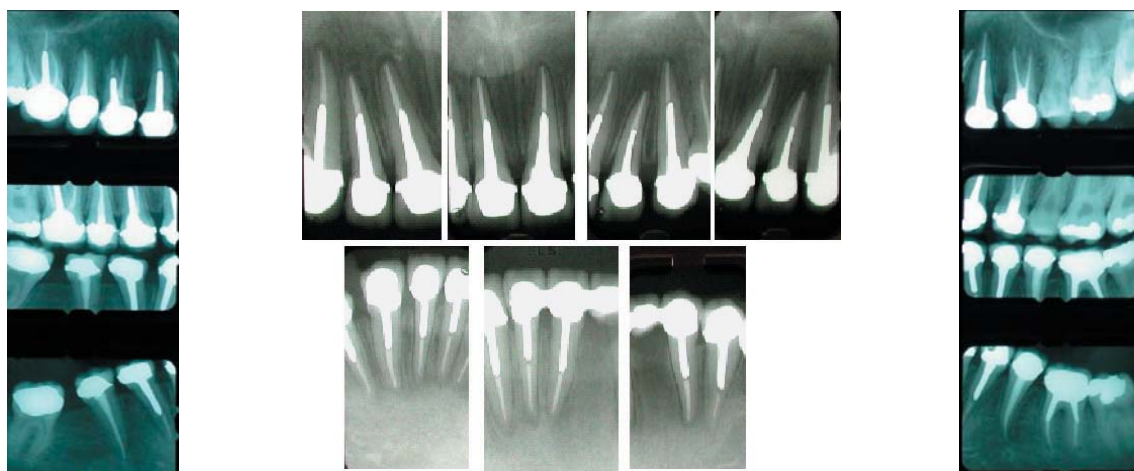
Radiographs at one year recall.
